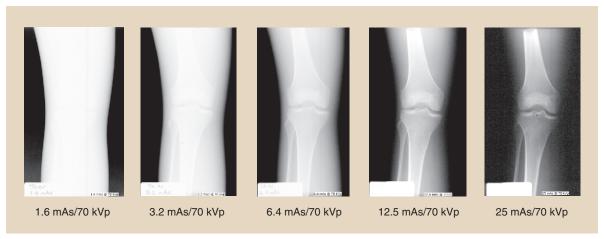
Improper radiographic technique with a screen-film image receptor results in an unacceptable image. (Courtesy Betsy Shields, Presbyterian Hospital, Charlotte, North Carolina.)
